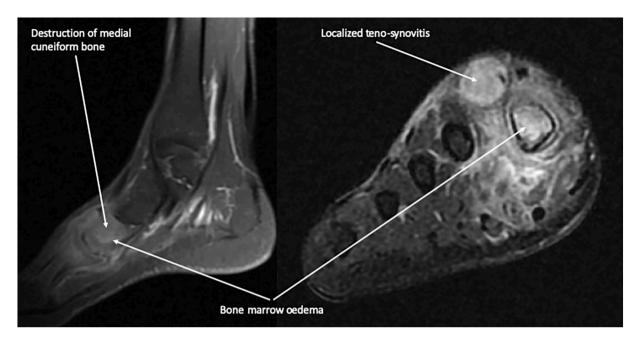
Degenerative changes are seen in MRI of the 1st TMT joint. Joint destruction, bone marrow edema, and joint effusion extending to dorsal aspect of mid foot causing a prominent localized teno-synovitis are shown.
